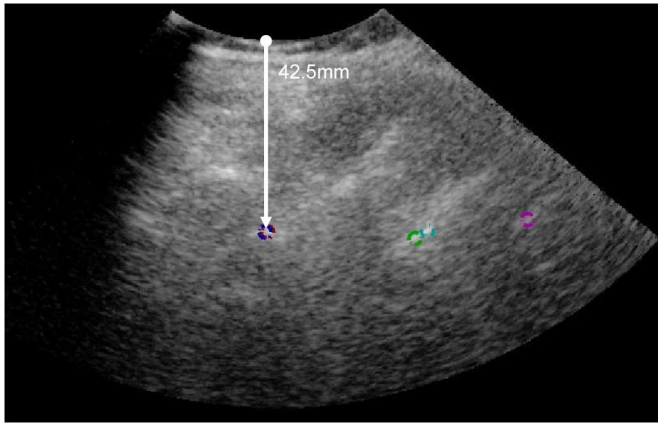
Ultrasound image of the lumbar anatomy with the LF detected, showing the skin-to-LF depth and the automatic measurement as an overlay.
